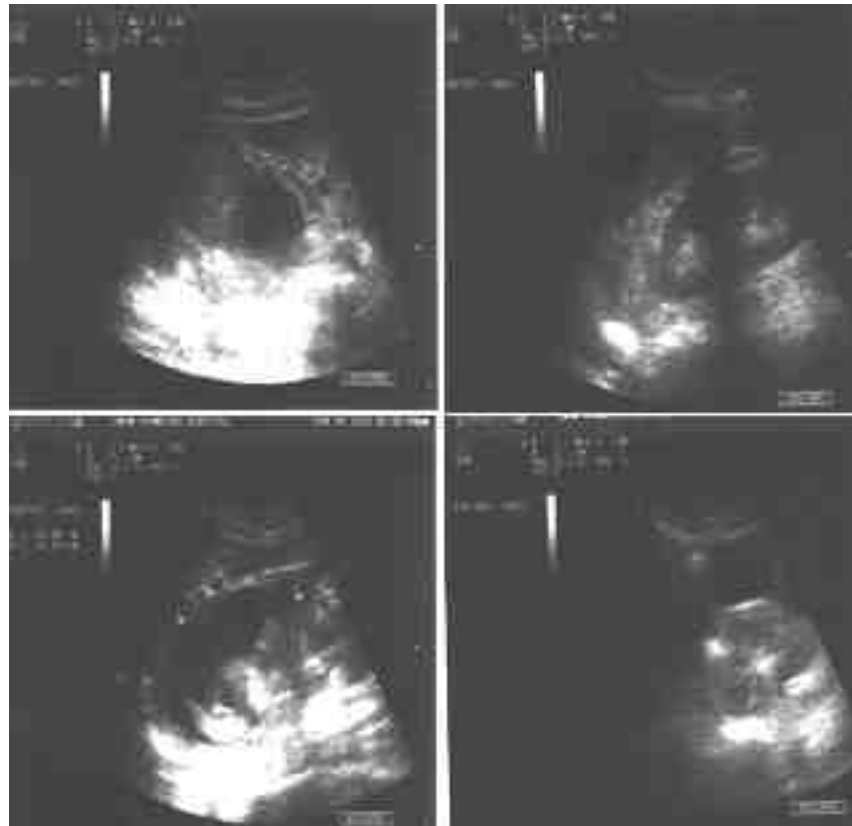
Abdominal Ultrasonography showing a large cystic and solid mass in right adrenal lodge with retroperitoneal hematoma and some free fluid in abdominal cavity.
